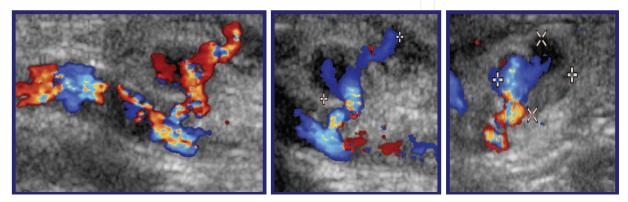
Pseudoaneurysm of the radial artery (2D color-Doppler flow imaging)
